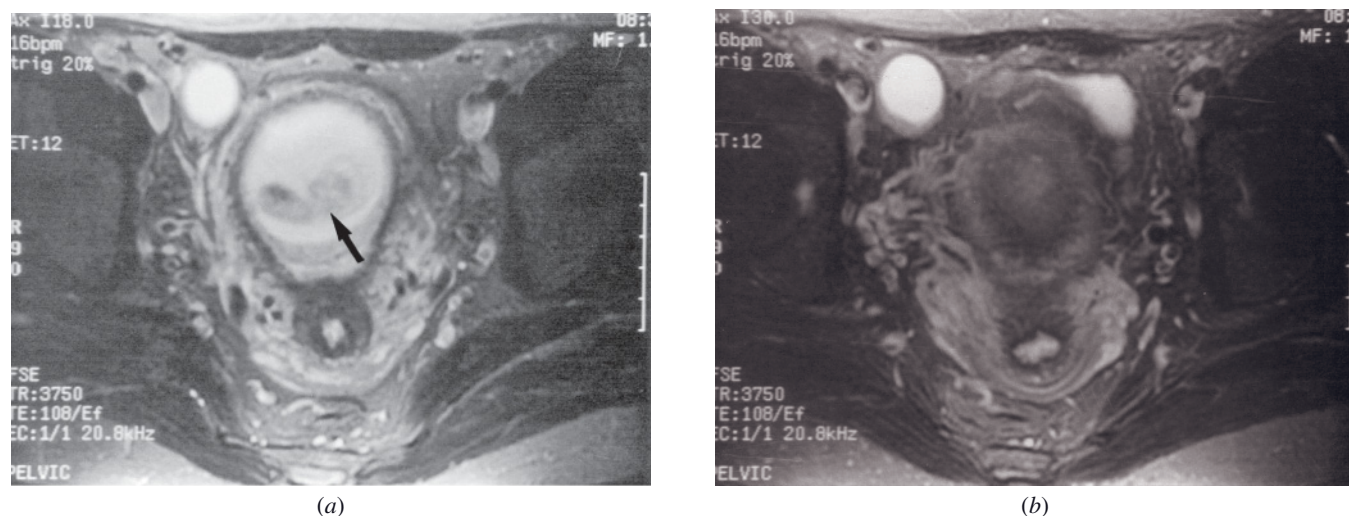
FIGO stage I cervical carcinoma in a pregnant patient at 11 weeks of gestation. Transverse T2-weighted ETSE images (*a*, *b*). Although the cervical carcinoma itself is not clearly visualized, the hypointense cervical stroma is not disrupted and therefore parametrial invasion could be excluded. Trachelectomy was performed, and definitive treatment was delayed until delivery (arrow, *a*: fetus).
